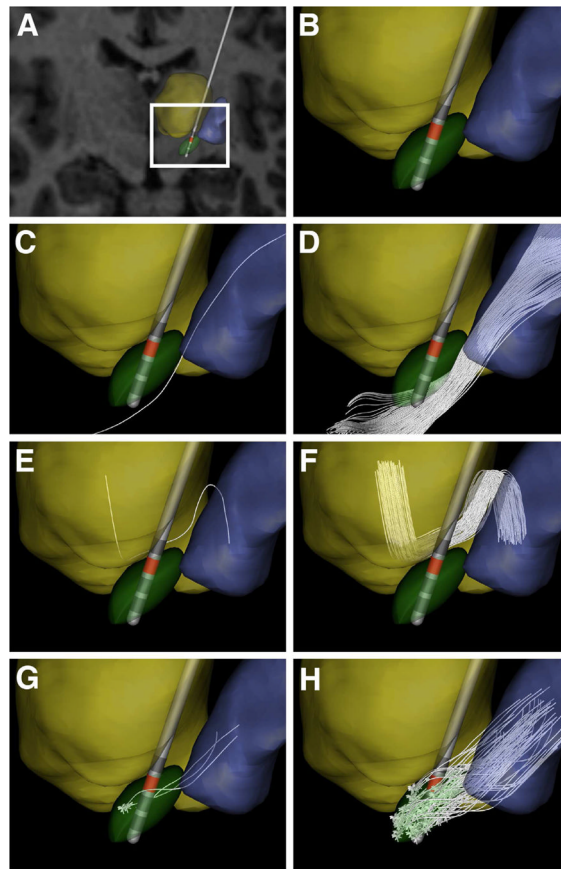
Anatomical model. (A) MRI brain atlas with a typical electrode position for STN-targeted DBS, along with relevant nuclei (thalamus – yellow volume; STN – green volume; GP – blue volume). (B) Zoomed-in version of the nuclei and electrode position. (C) A single IC axon defined via tractography. (D) 200 unique IC axon trajectories reconstructed from a seed region just lateral to the STN. (E) A single GPI axon passing through the lenticular fasciculus. (F) The initial axon trajectory was randomly copied within a predetermined region of interest to create a GPI bundle consisting of 80 fibers. (G) Three different STN neurons (including dendrites, soma, and axon). (H) These three initial neurons were replicated within the STN nuclei boundaries to create 100 total STN projection neurons.
